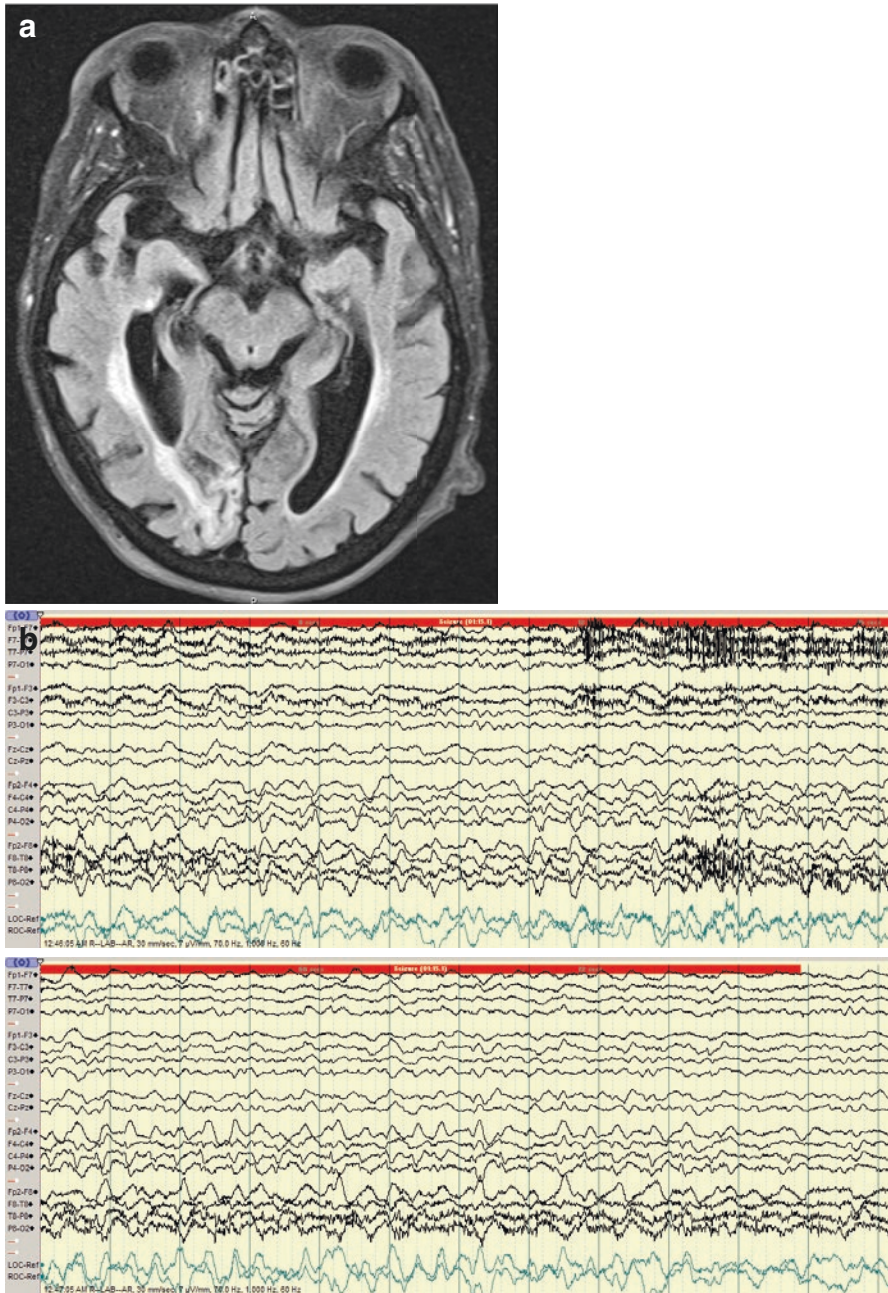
(a) Brain MRI of a 76-year-old female with history of an ischemic stroke over the left parietal region 8 weeks ago, presenting after collapse at home. (b) The ictal EEG shows a seizure consisting of an evolving theta frequency discharge over the left hemisphere, maximal over the frontocentrotemporal region
